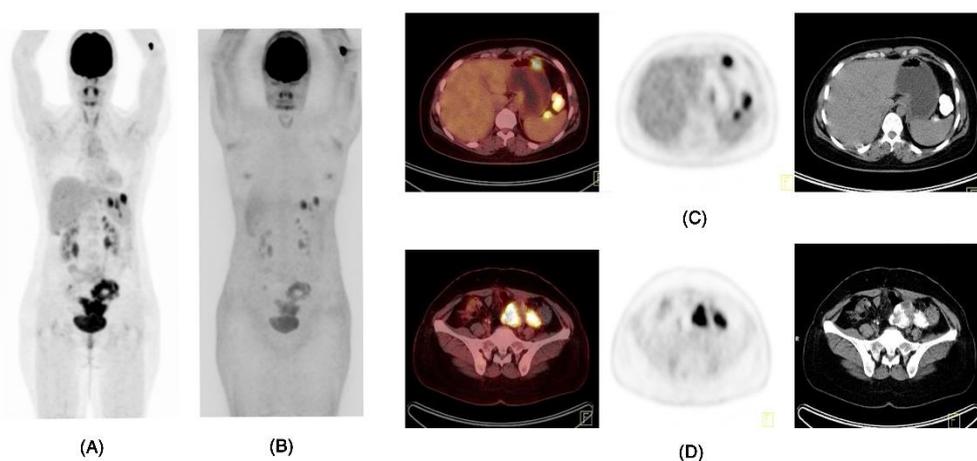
Maximum intensity projection (MIP), both CT attenuation corrected (A) and attenuation uncorrected images (B) demonstrate increased metabolic activity in calcified lesions in the abdominopelvic region. PET/CT fusion (right), PET (middle) and axial CT (left) images demonstrate calcified lesions with increased FDG uptake in the perisplenic and perigastric region (C) as well as in the left pelvic cavity (D)
